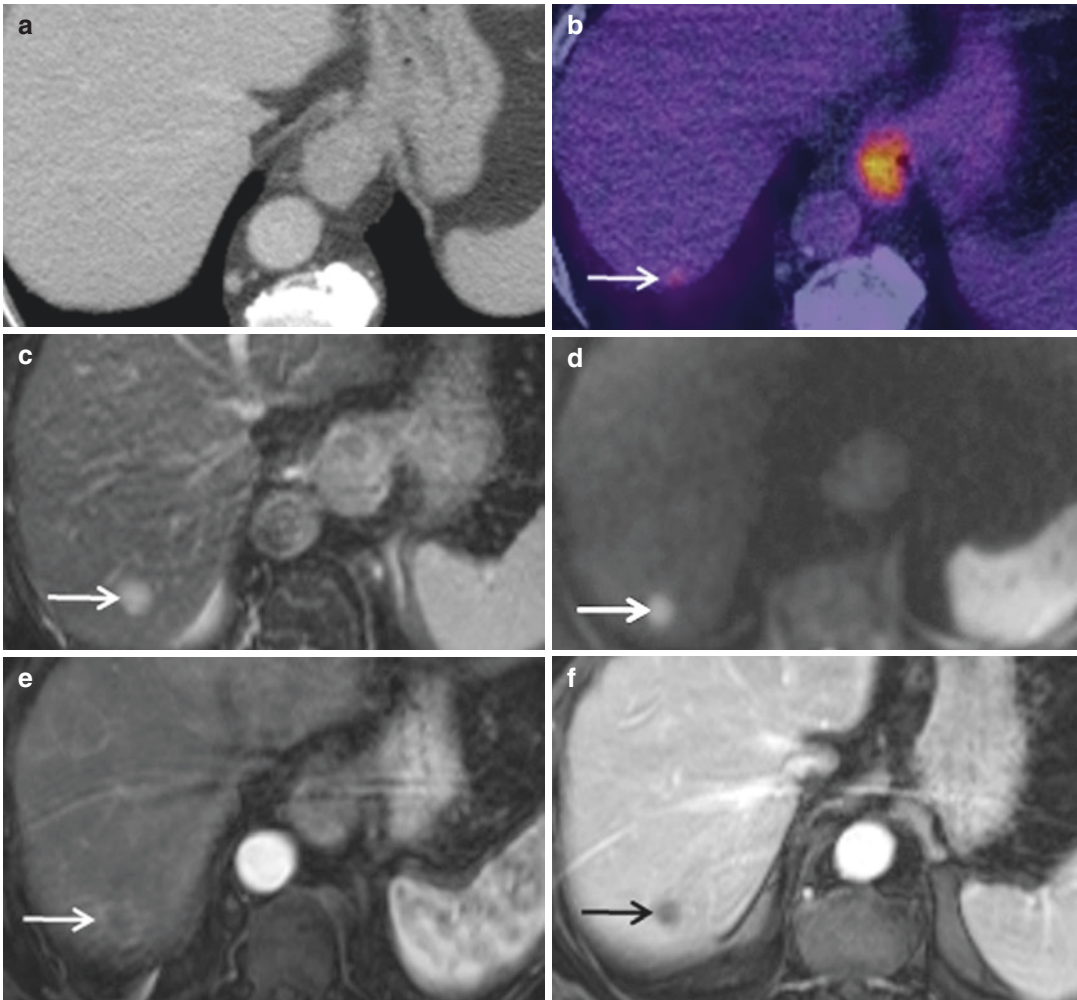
The staging CT (a) did not show any focal liver lesions. The PET-CT (b) showed a possible lesion in segment VII of the liver (arrow). The T2-weighted MRI (c) confirmed a focal lesion at this position (arrow), which
